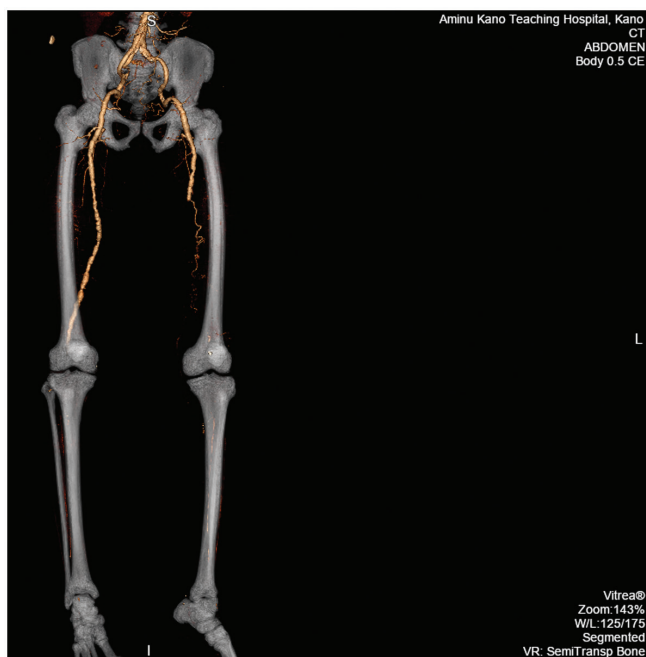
A frontal view of 3D/volume-rendered CTA of the terminal abdominal aorta and both lower limbs, showing abrupt termination of the flow of contrast medium in the right popliteal and proximal left femoral artery
